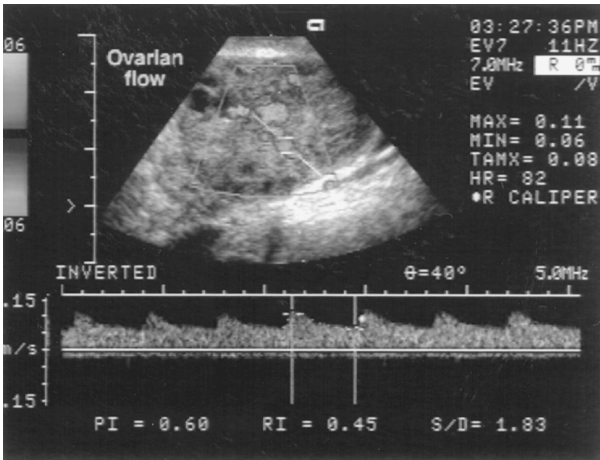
Flow map and Doppler spectrum for ovarian blood flow.
